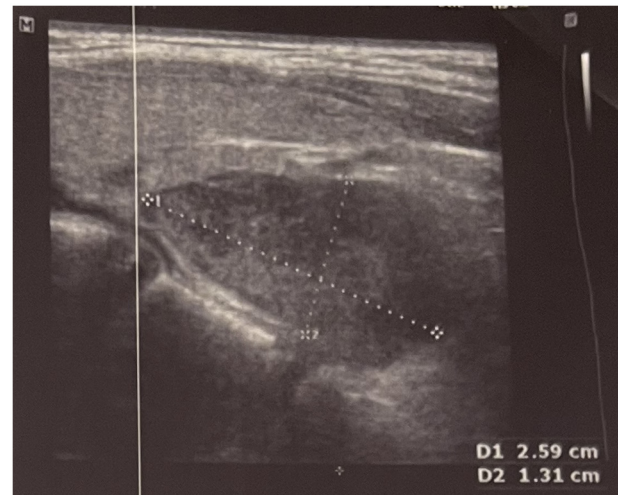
Ultrasound of the parathyroid glands demonstrating a well-defined vascular hypoechoic lesion of 13x26 mm in size located in the right infrathyroid area suggestive of a parathyroid adenoma.
